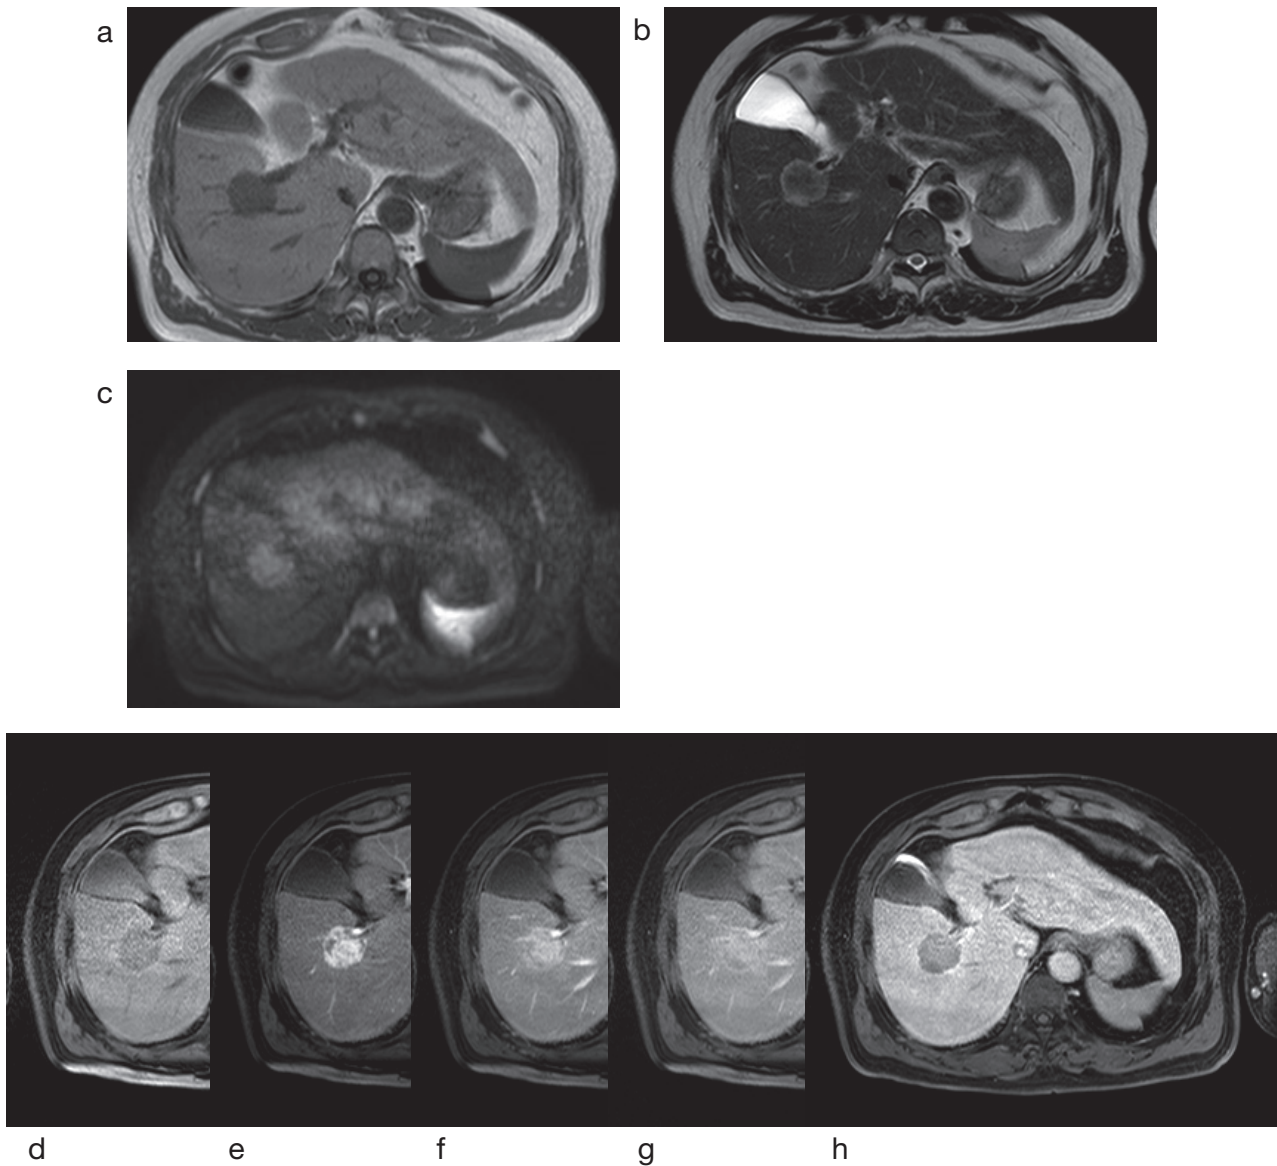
Magnetic resonance images
